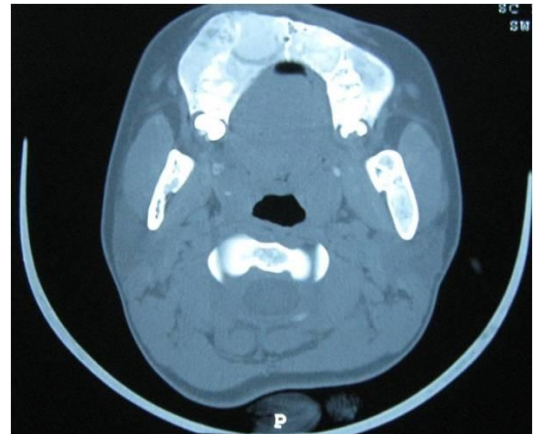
Computed tomography scan of craniofacial region
